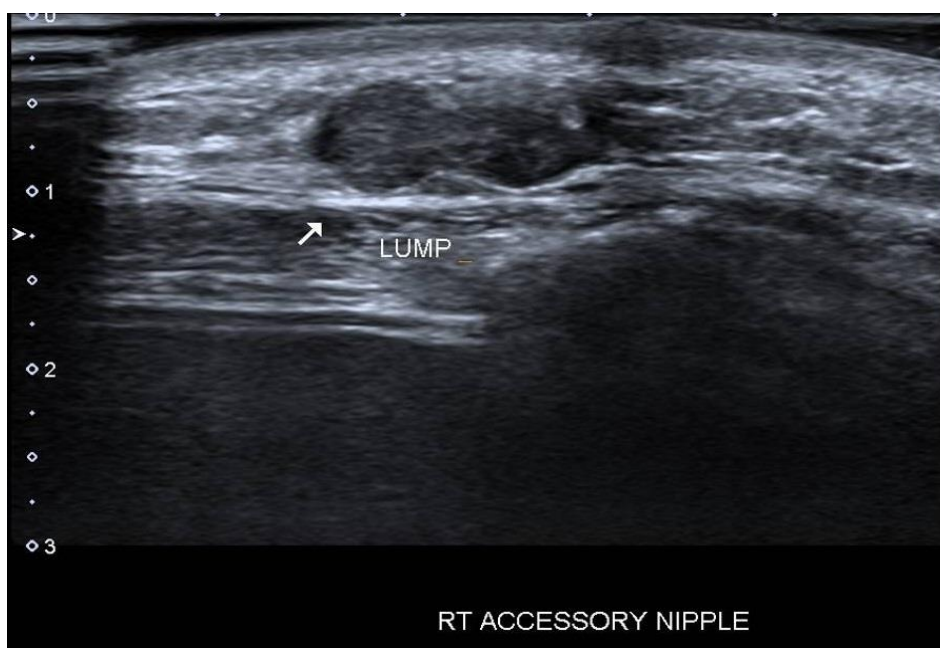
Ultrasound scan of palpable lump adjacent to accessory nipple.
